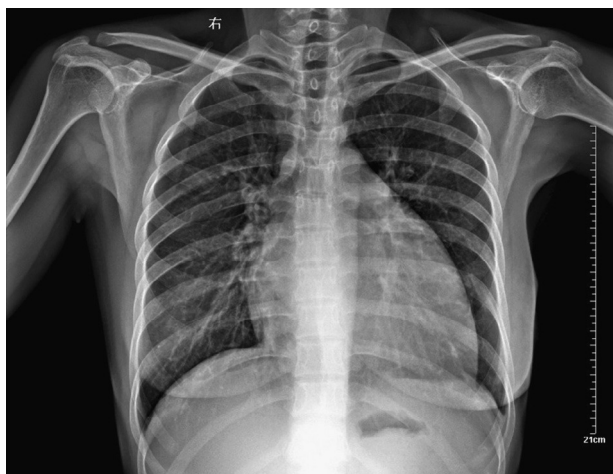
Chest radiography showed an enlarged and globular cardiac silhouette and pulmonary congestion without pleural effusion.
